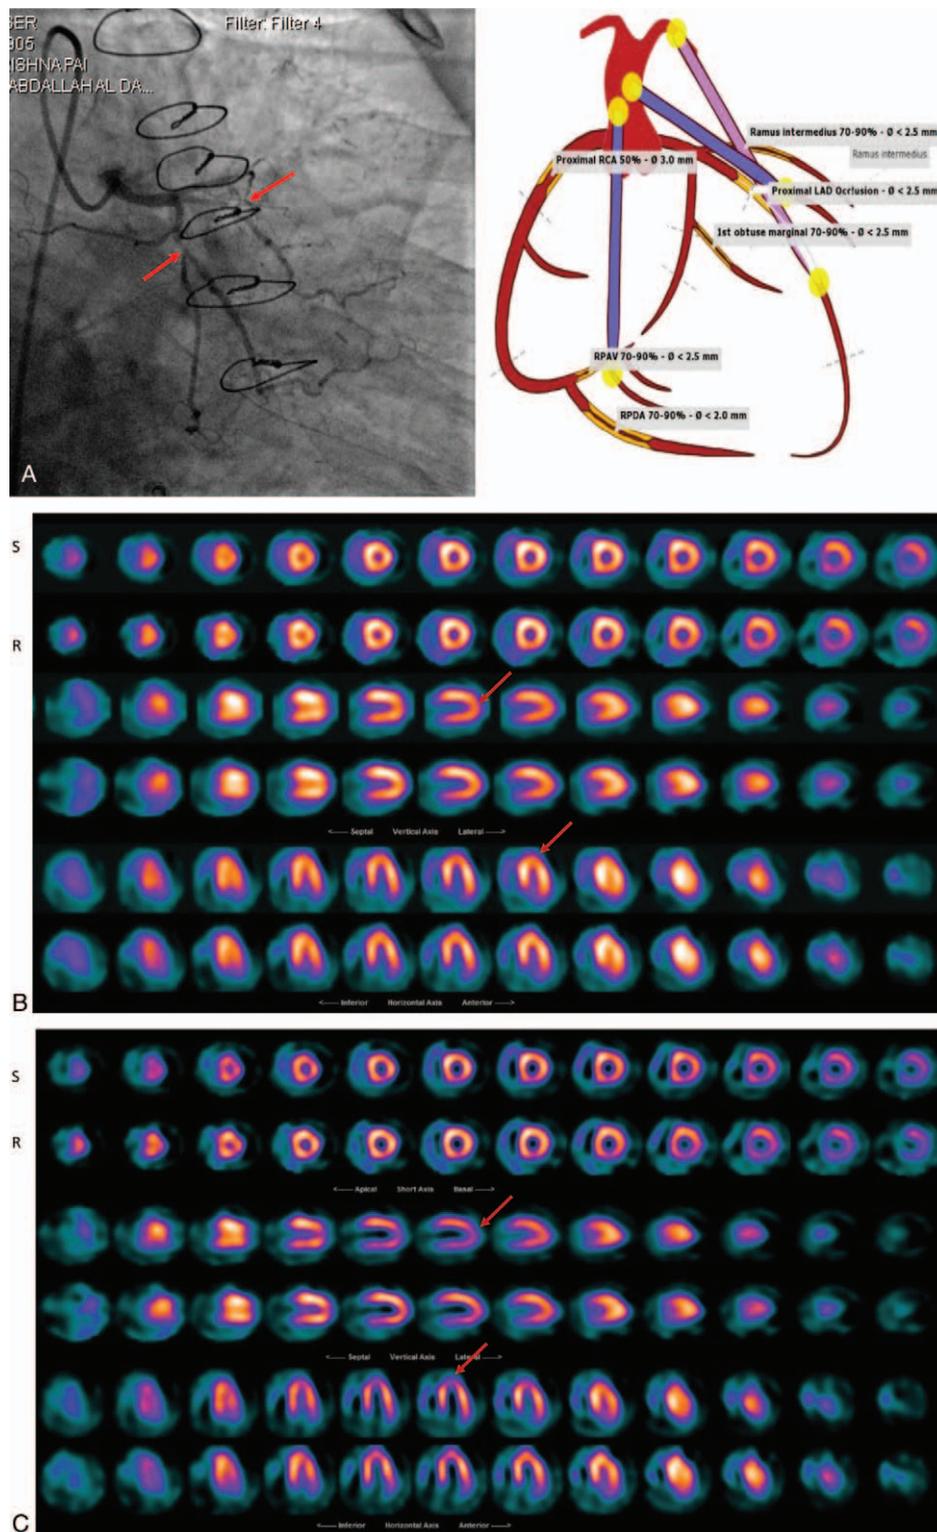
A 53 years old male patient with the history of CAD was referred to NM for evaluation of myocardial perfusion post CABG. (A): Angiography result reported triple vessels disease, (B): Butterworth reconstructed SPECT results reported mild degree of ischemia in apex, (C): Wiener reconstructed SPECT results suggested severe diffuse uptake in anterior and anterolateral walls with moderate diffuse uptake in apex that was more consistent with angiography. CABG = coronary artery bypass grafting, CAD = coronary artery disease, SPECT = single photon emission computerized tomography.
